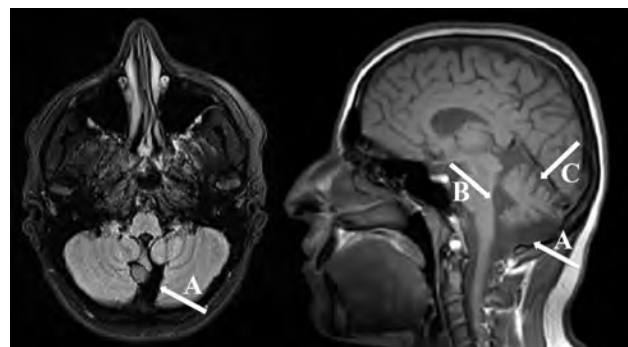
MR cross-sectional (*left*) and midsagittal (*right*) T1-weighted scans showing enlargement of cisterna magna (A), enlargement of the fourth ventricle (B), and partial hypoplasia of the cerebellar vermis (C).
